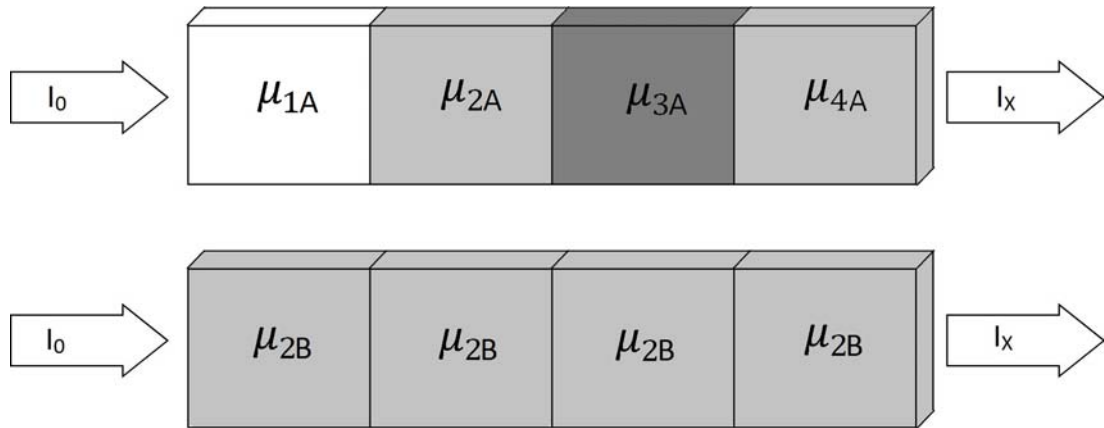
Similar total attenuation in two different situations. At the top, a beam passes through an area with different densities while, below, it passes through an area with uniform density. CT is able to discriminate between one case and the other, while X-rays are not. Example taken from [8].
